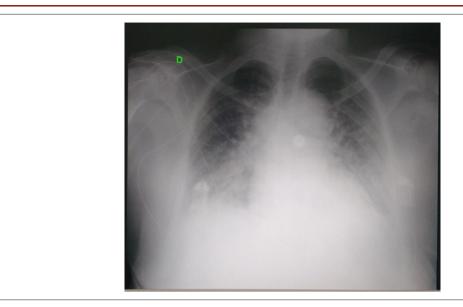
Chest x-ray revealing enlarged cardiac silhouette and bilateral pulmonary congestion.
